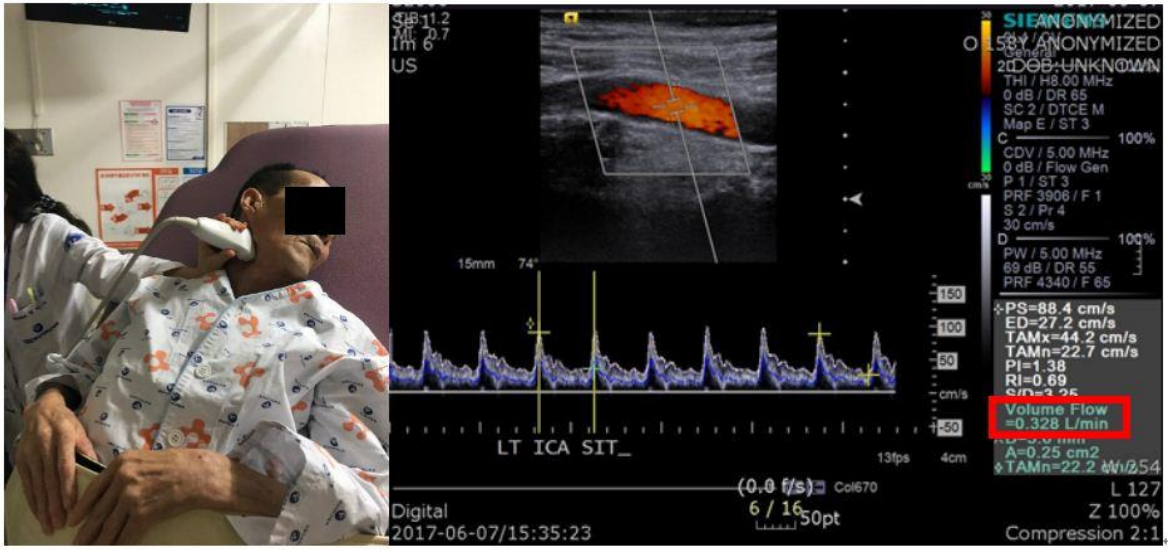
The position of patient and blood flow velocities measured by duplex ultrasonography
